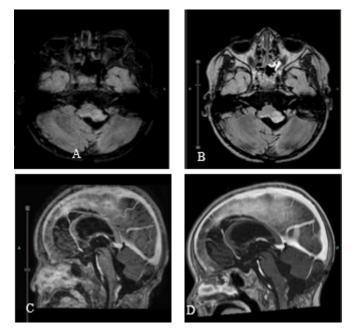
On the left (A-C): last follow-up MRI before the acute event (10 days before). On the right (B-D): MRI during the acute event. A-B Axial FLAIR weighted sequences. C-D Sagittal T2 weighted sequences with contrast medium. The residual cervical-medullary lesion involving the dorsal region of medulla oblongata, the cervical cord down to C3, and inferior cerebellar peduncles (> left) is remained the same comparing the last follow-up MRI and the MRI performed during the acute event. The contrast enhancement is remained the same. No evidence of new elements is shown, excluding a disease progression to explain the patient's neurological status.
